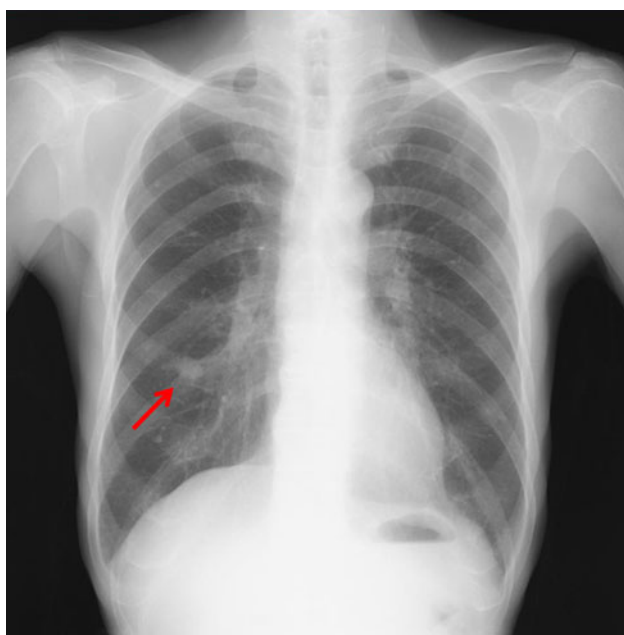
Chest radiography showing a nodular shadow, 16 mm in diameter, in an area overlapping the anterior edge of the right 5th rib
